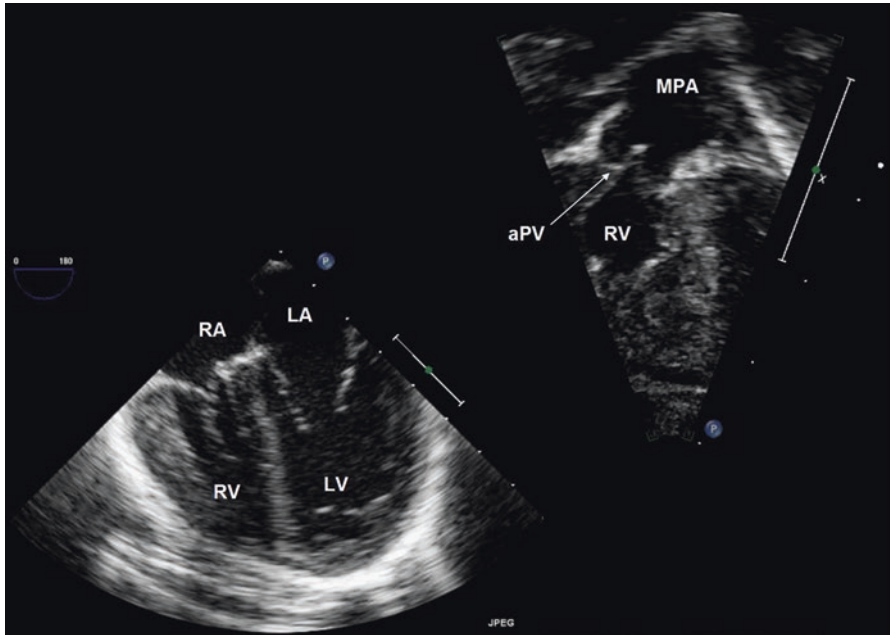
Transesophageal and transthoracic echocardiographic images of pulmonary atresia with intact ventricular septum. Note the relative right ventricular hypoplasia compared to the left ventricle. Tipping the echo probe more anteriorly demonstrates an atretic pulmonary valve (aPV) that does not open, arising from a diminutive right ventricle (RV). RA right atrium, LA left atrium, LV left ventricle, MPA main pulmonary artery
